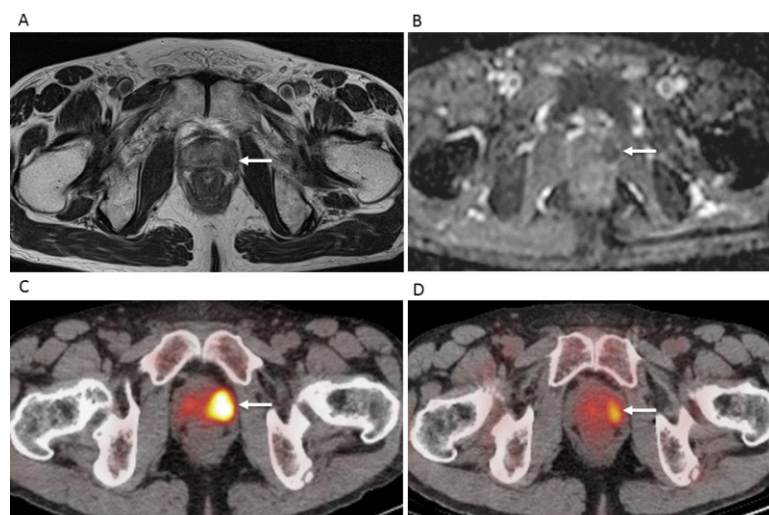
Images from a 68 year old male with prostate cancer, Gleason score 4+5=9 [cT2bN0M1, initial prostate specific antigen (PSA) 104ng/mL]. (a) Low signal intensity area in left peripheral zone (arrow) shown by T2WI, suggesting prostate cancer. (b) Apparent diffusion coefficient (ADC) map showing low signal intensity area in left peripheral zone (arrow), with a mean ADC value of 0.802mm²/s, confirming prostate cancer. (c) ¹¹C-choline PET/CT image showing strong ¹¹C-choline uptake [maximum standardized uptake value (SUVmax): 6.31] in left side of prostate (arrow), confirming prostate cancer. (d) ¹⁸F-FDG PET/CT image showing weak ¹⁸F-FDG uptake (SUVmax: 3.47) in left side of prostate (arrow).
